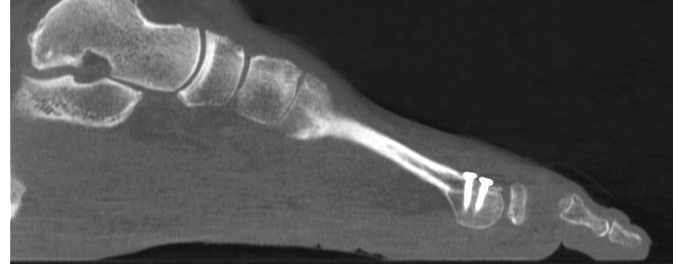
Postoperative weight-bearing computed tomography sagittal slice.
